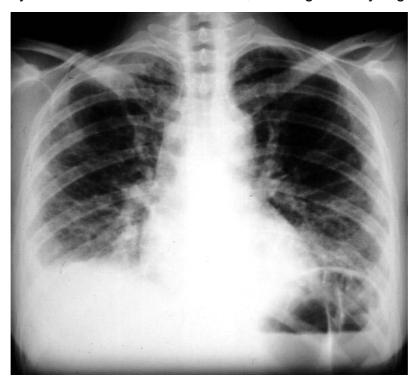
pneumoniae induced community acquired pneumonia, X-ray radiograph.
